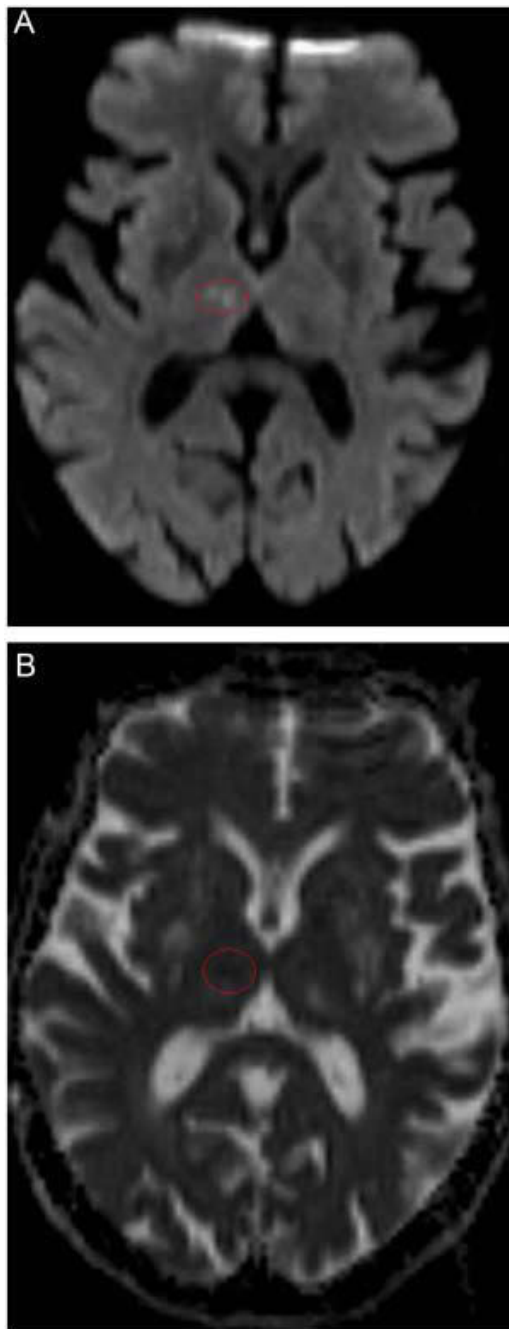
A) Diffusion-enhanced (b 1000) magnetic resonance imaging in the axial plane, along with its corresponding ADC map. B) In the right thalamus, there are 2 point foci of signal hyperintensity on the diffusion-enhanced image and hypointensity on the ADC image for acute-subacute infarcts (a lesion with inverse behaviour in relation to chronic infarction is identified in the left thalamus). These foci were not visible on conventional T2-enhanced sequences or fluid-attenuated T2 (FLAIR).
